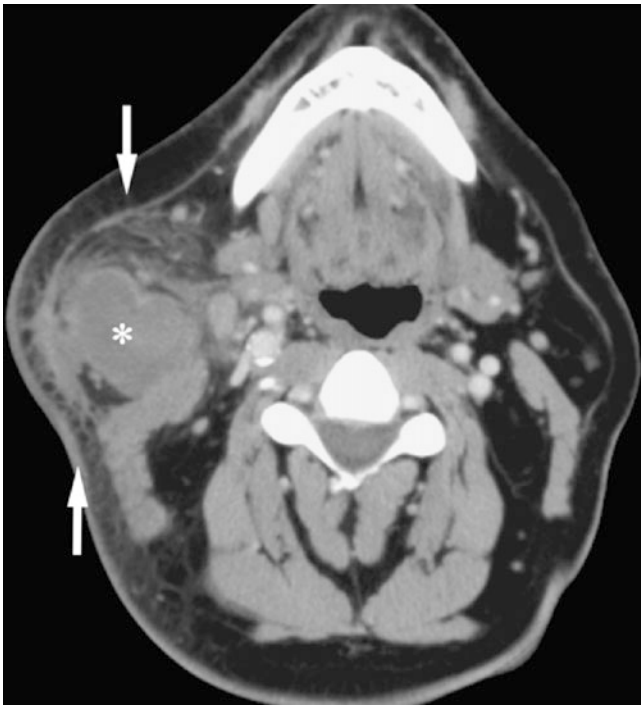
Parotid abscess; 52-year-old male with non-resolving right parotitis. Axial post-contrast CT image shows homogeneous density with contrast-enhancing rim consistent with abscess in parotid gland (*asterisk*) with fat stranding and thickening of platysma (*arrows*)
